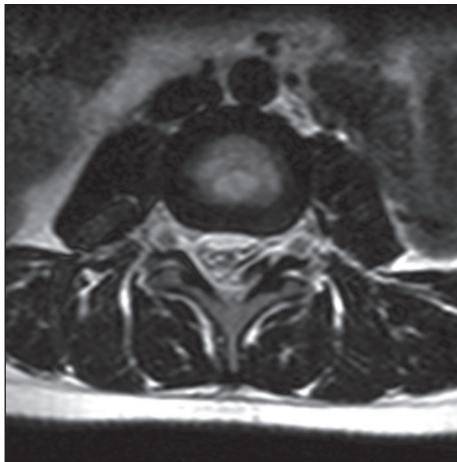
Preoperative axial MRI showing hematoma compressing lumbar dural sleeve
